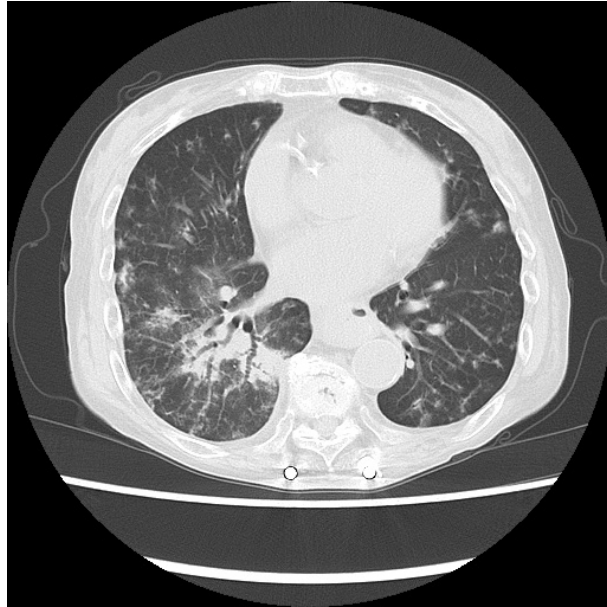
Chest computed tomography on admission showing bilateral consolidation and reticular shadows. Metallic spinal implants are visible.
